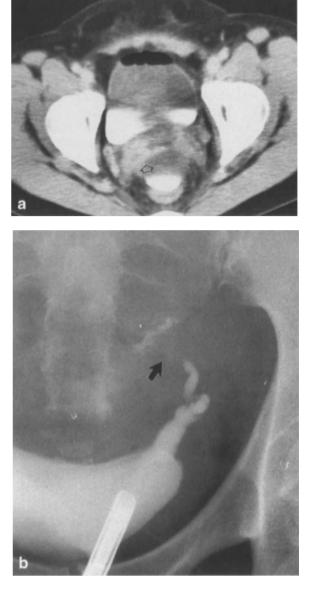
a Computed tomogram performed for early postoperative fever after abdominal hysterectomy. Contrast material can be seen in the cul-de-sac (*arrowhead*). b Retrograde ureterogram confirms site of ureteral injury and leak in the pelvic ureter (*arrow*)
